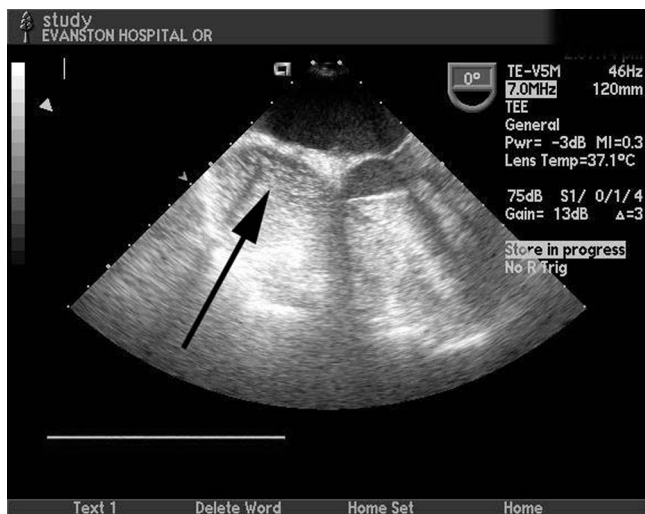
Demonstration of numerous air bubbles in the right atrium with transesophageal echocardiography. The bubbles were generated by the administration of 10 ml of a blood/saline solution from a flushing-sampling arterial pressure system into a vein at the level of the wrist.
